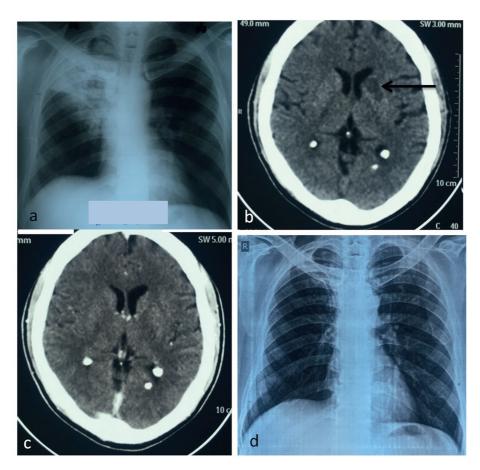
a) X-ray chest P-A view showing collapse with consolidation of the right upper lobe b) CT head showing a hypodense lesion (Black arrow) in the left basal ganglia c) follow up CT (after 2 months) showing complete resolution of the lesion d) X-ray at the end of treatment showing resolution of the parenchymal lesion with mild fibrosis.
